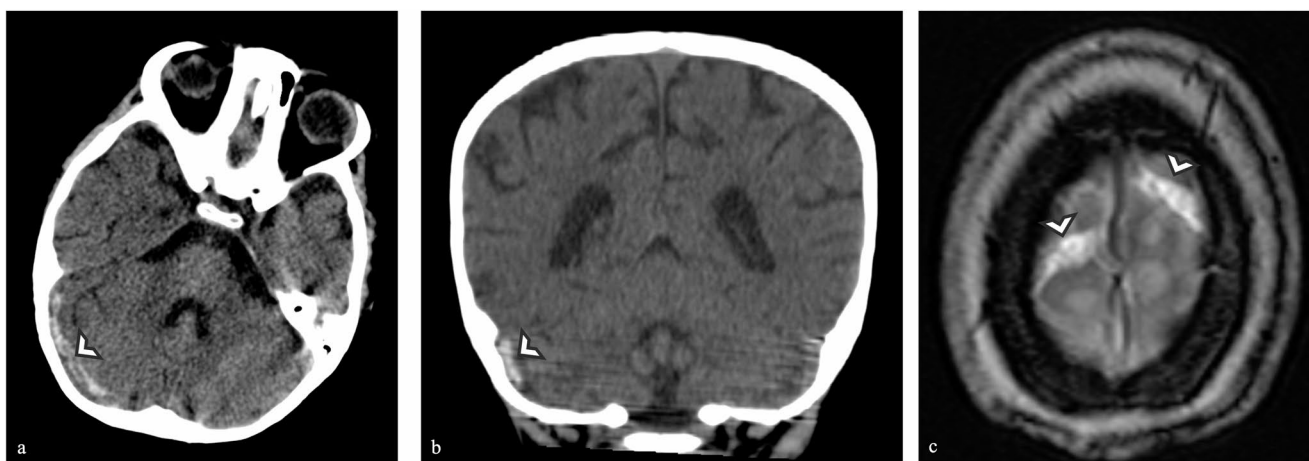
Four-year-old boy with B-cell acute lymphoblastic leukemia under treatment with blinatumomab who had an episode of reduced responsiveness accompanied by upward eye deviation. The axial and coronal plain CT demonstrated hyperdense areas in the right transverse sinus (white arrows in a and b) suggestive of thrombosis. In c, a
